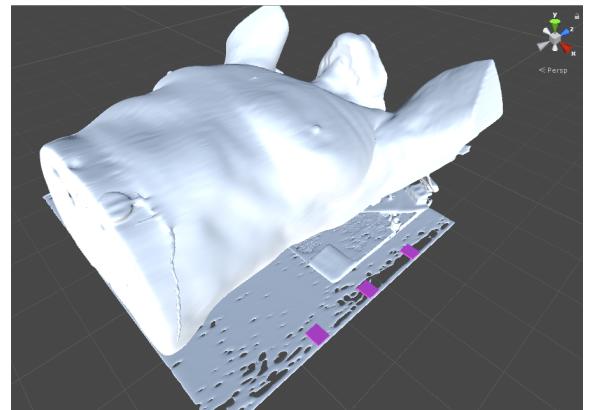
A hologram constructed from a CT scan.
